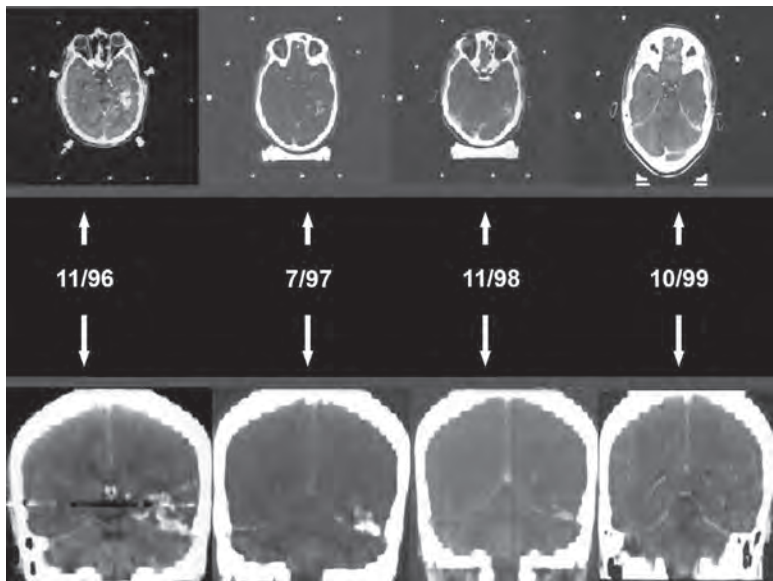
Serial CT showing progressive reduction in nidus size
